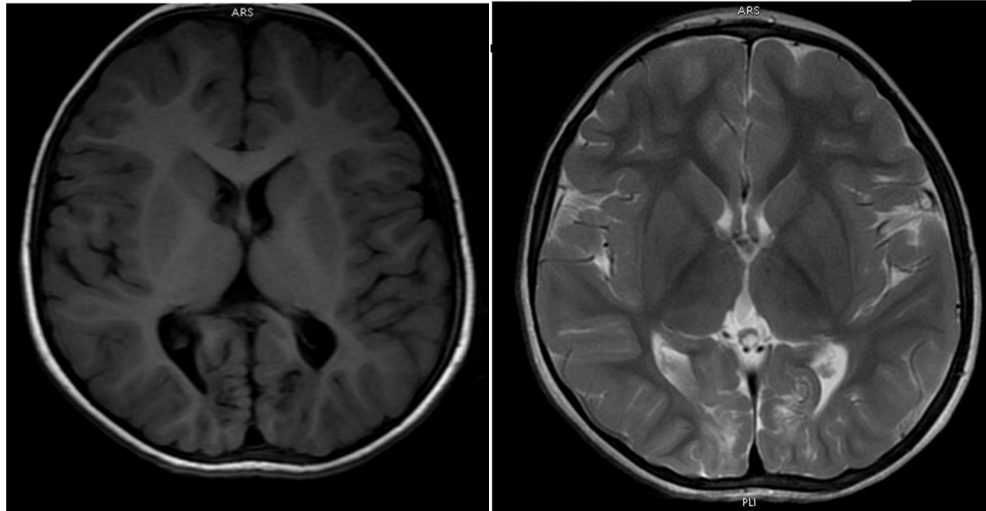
MRI Brain : T1 and T2WI axial sections shows perinatal hypoglycaemic and hypoxic occipital injuries.
